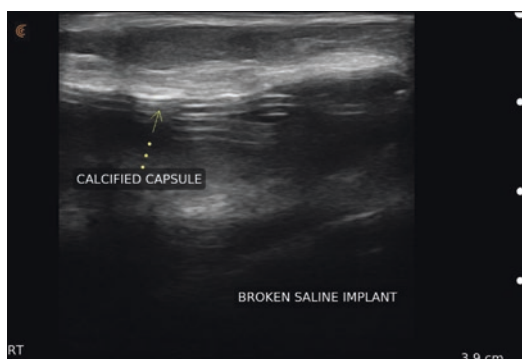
Grayscale ultrasound image of broken saline breast implant with a hyperechoic appearance of the implant capsule suggesting calcification of the capsule
